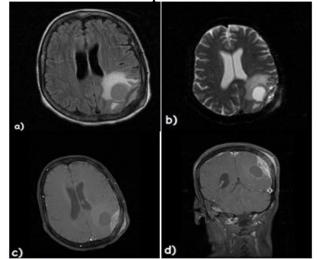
Brain MRI a) T2 FLAIR, b) T2, c+d) T1 post Gadolinium: left parietal cystic lesion with peripherical enhancement, invading the left calvarium and soft tissue.
